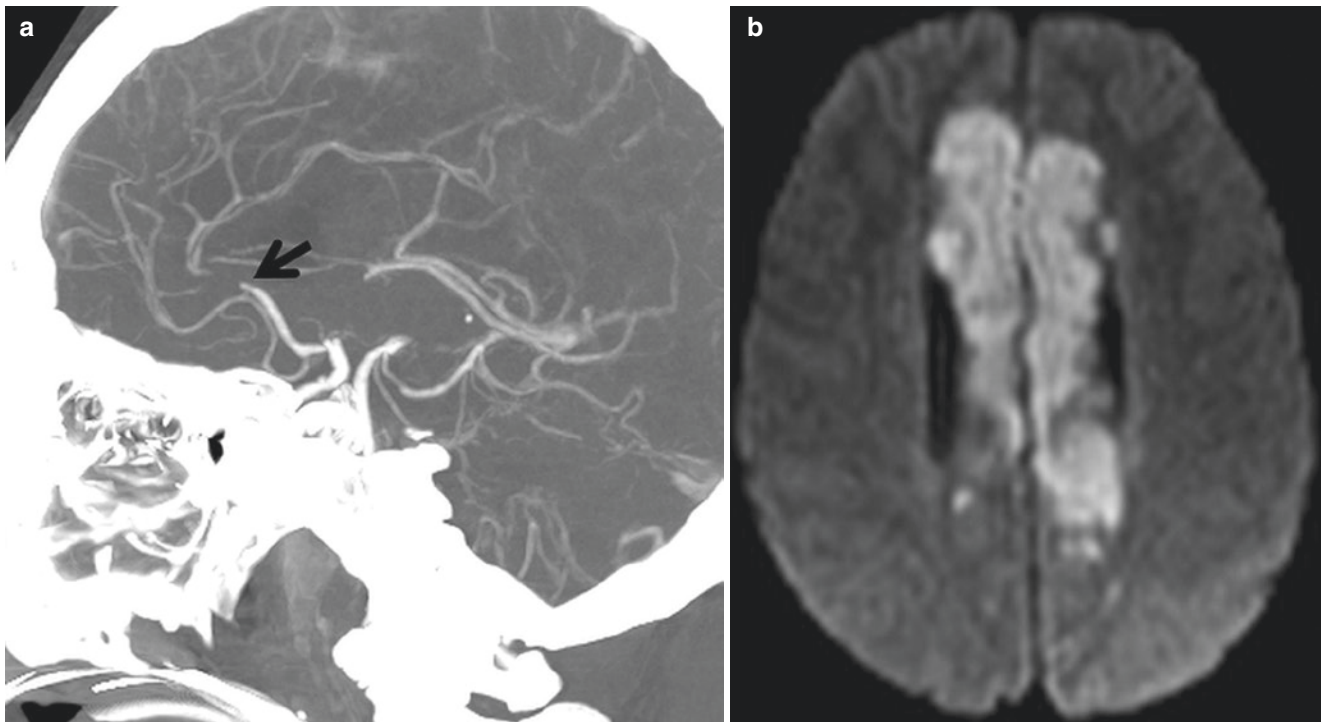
Bihemispheric ACA infarction. (a), Sagittal CTA shows the occlusion of a dominant distal left ACA A2 segment (arrow). (b), DWI demonstrates infarction of bilateral ACA territories. Note the right ACA
